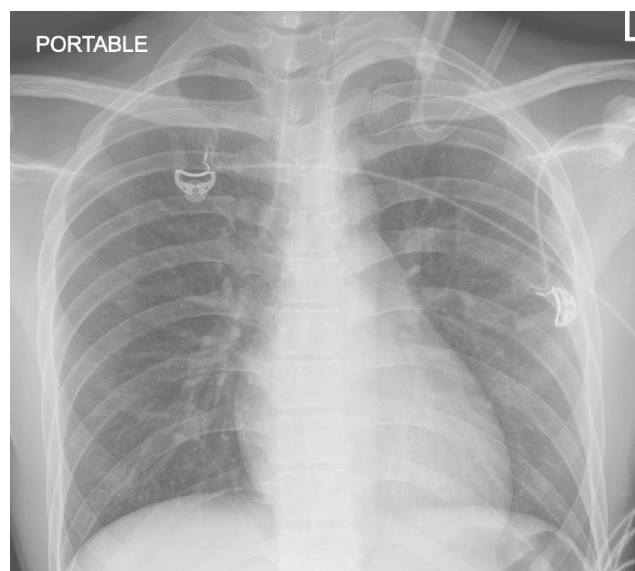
Chest radiograph image taken on arrival to the emergency department was normal
